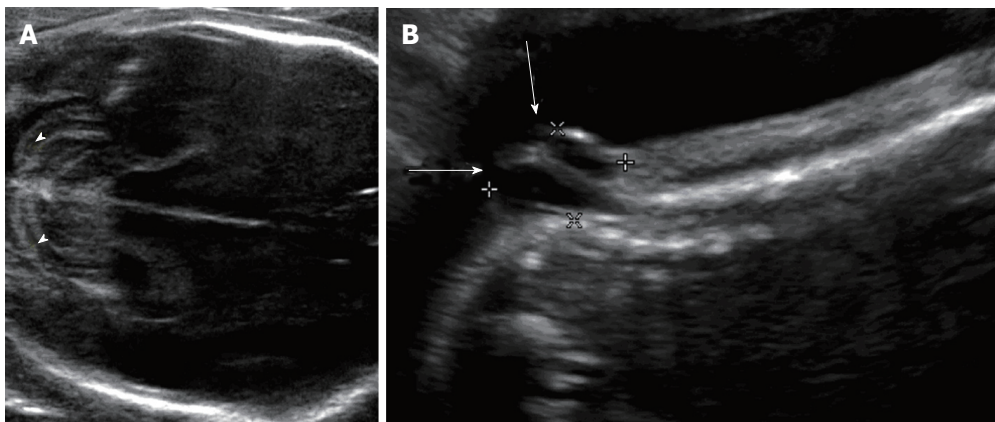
Chiari ultrasound. Grayscale ultrasound images of the 23 wk fetal head (A) and spine (B) demonstrate curved, "banana-shaped" appearance of the fetal cerebellum (arrowheads) typical of Chiari II malformation, as well as associated lower sacral myelomeningocele (arrows).
